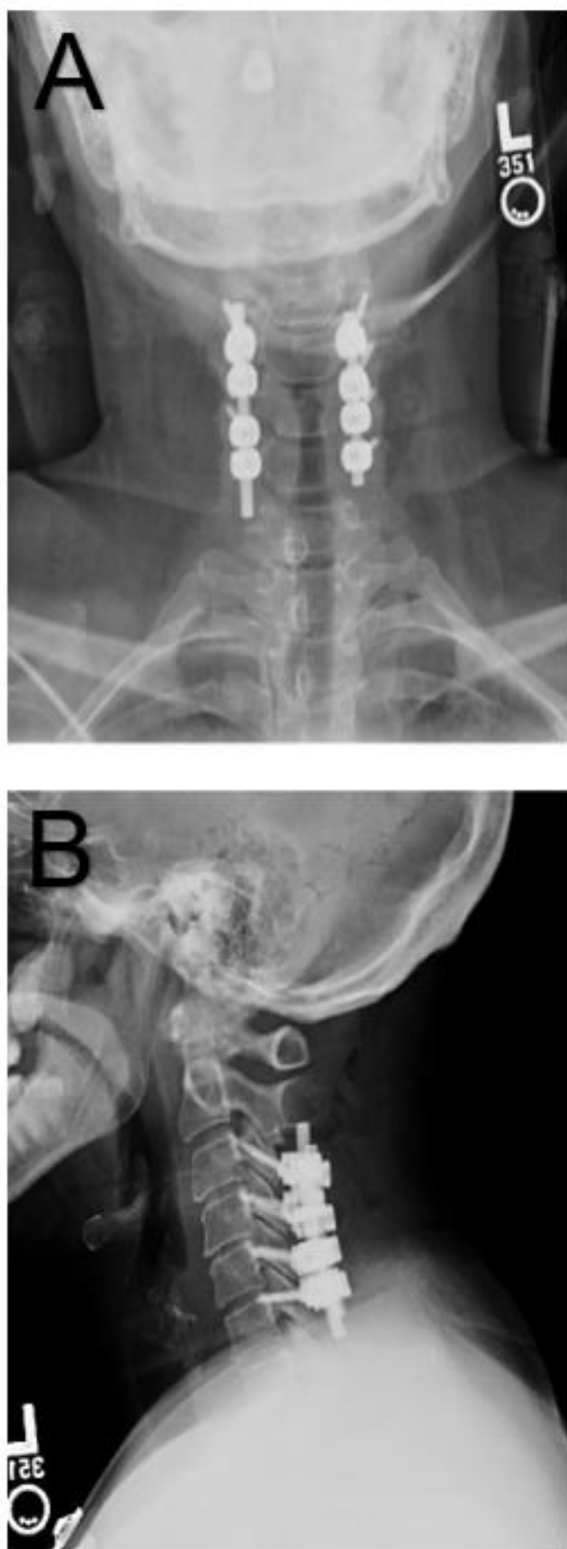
Cervical spine radiographs, AP and lateral views. Images show intact posterior fusion hardware associated with recent laminectomies and posterior fusions from C3 through C6 with bilateral pedicle screws and vertical struts. No prevertebral soft tissue swelling. No spondylolisthesis. Mild background narrowing of C4–C5 is unchanged with small anterior osteophytes along several levels.
